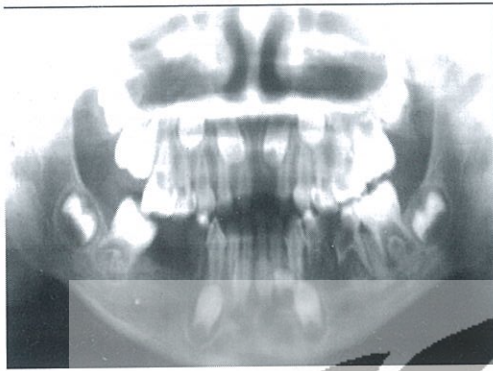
Panoramic radiographic imaging
